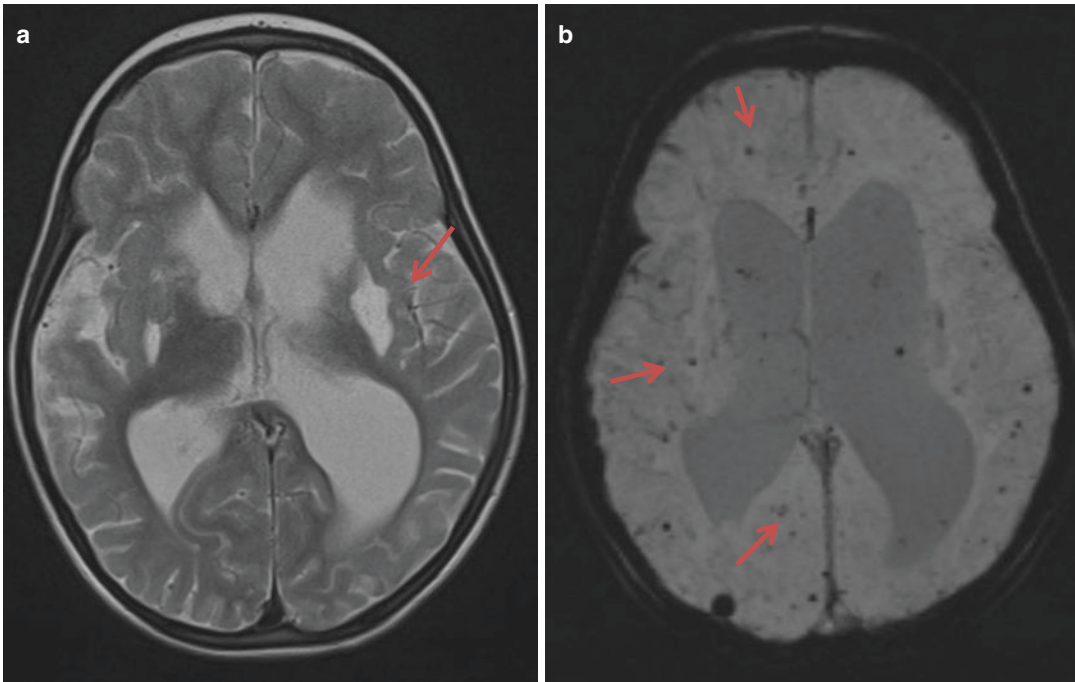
Magnetic resonance imaging brain from a child with Aicardi Goutières syndrome caused by homozygous mutations in *ADARI*. (a) Shows bilateral basal
